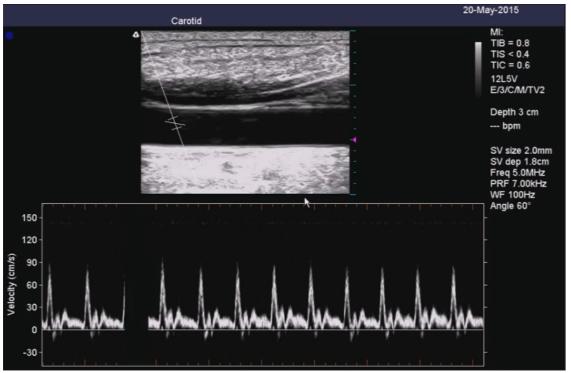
Example of a representative example of the ultrasound velocity and diameter measurement of the carotid artery during the cold pressor test.
